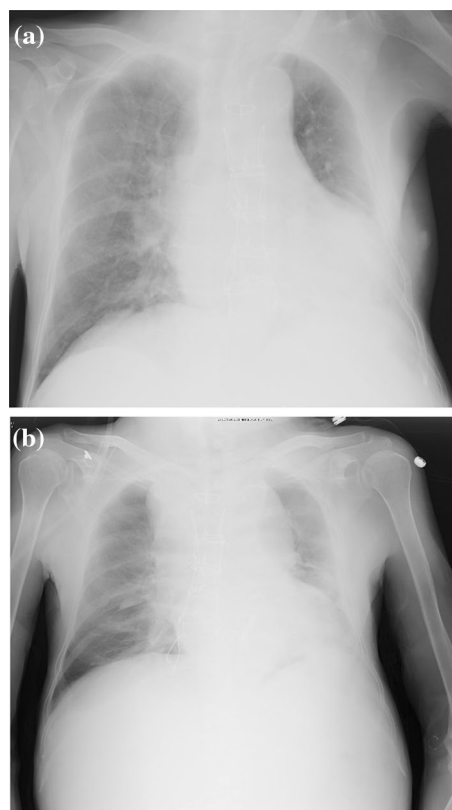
Chest X-rays of the patient. Chest X-ray of the patient on admission day (a) and after the hemodialysis (b). a Mild cardiomegaly with a slight pulmonary congestion was observed on admission day. b Expanded upper mediastinum was demonstrated after the dialysis
